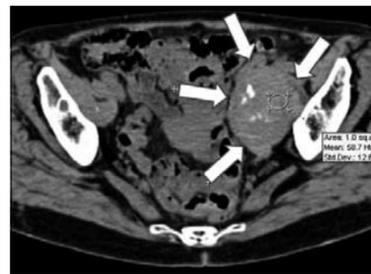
Multislice CT image of a female patient at 10-year follow-up showing a pseudotumour. Her cup inclination was measured to be 35°, cup anteversion 27° and femoral anteversion 30°. Cup inclination should always be below 50° and the combined femoral and cup anteversion should be below 45°. Excessive combined anteversion as in this case, or high inclination lead to edge loading and excess wear. The reason why female patients are more susceptible to pseudotumour formation perhaps relates to the fact that the etiology for the early hip arthritis which necessitates a resurfacing in these young females is often minor dysplasia with excess acetabular anteversion and excess femoral neck anteversion.
